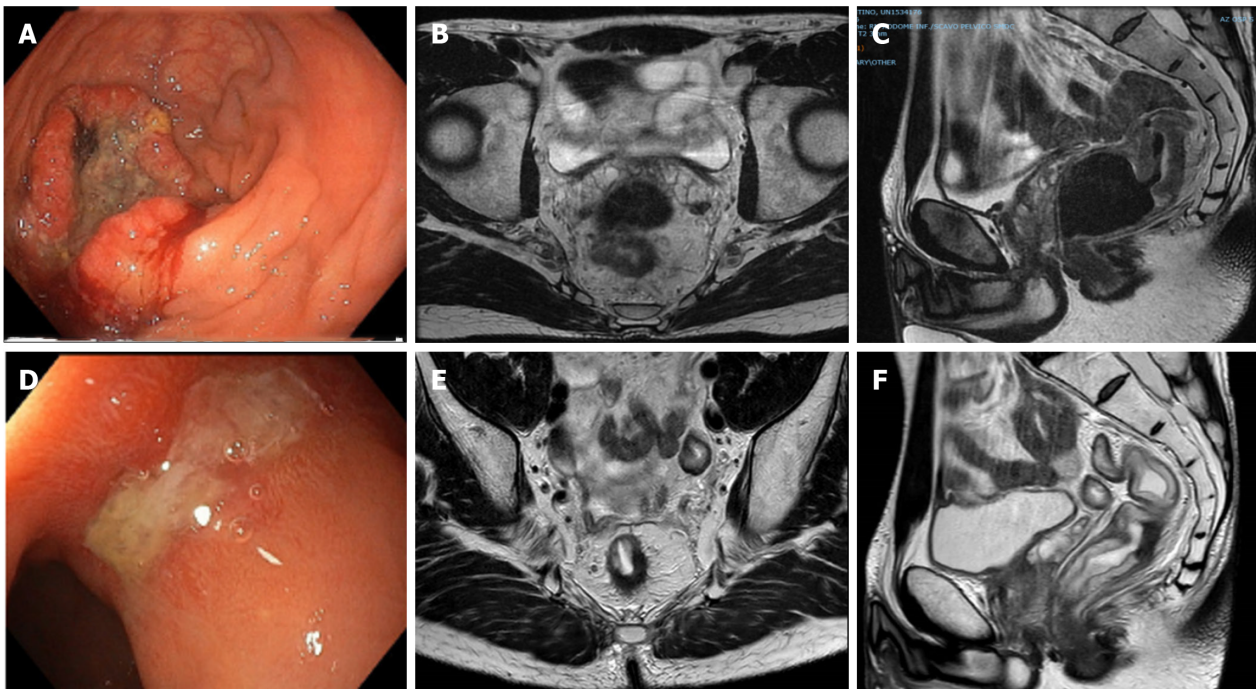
A case of clinical complete response confirmed at pathology. A-C: A 57-year-old female patient with rectal cancer. Endoscopy (A) and magnetic resonance imaging (MRI) (B and C) findings staged a tumour of the low of rectum (cT3aN0 mesorectal fascia negative, extramural vascular invasion negative, pelvic nodes negative). The patient underwent neoadjuvant chemoradiotherapy; D-G: Restaging at 15 wk after the beginning of therapy showed a clinical complete response at endoscopy (D), MRI (E), endorectal ultrasound (F), and 18-fluorodeoxyglucose-computed tomography/positron emission tomography (G).
